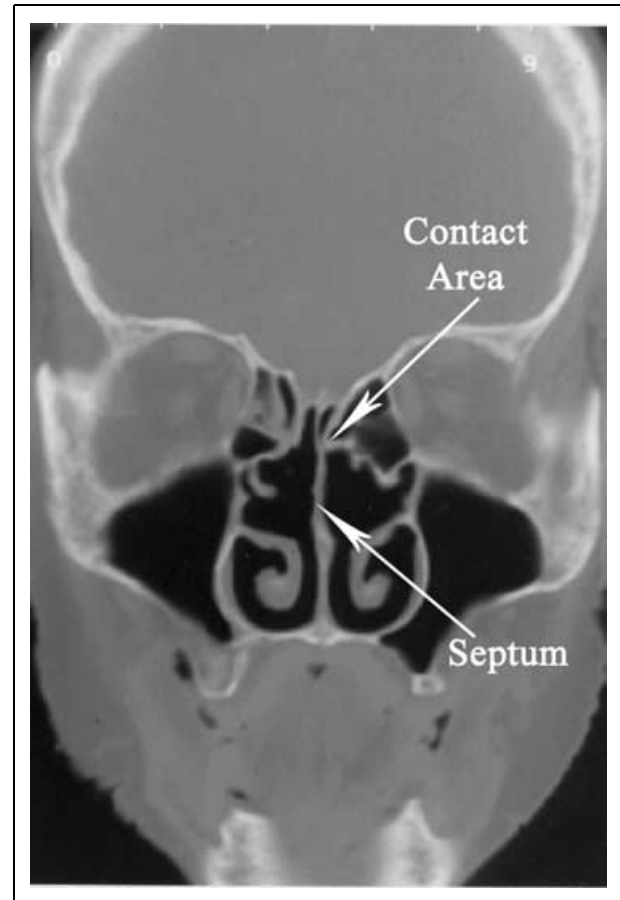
Shown above is a coronal CT of the sinuses. This patient has had a resection of the middle turbinate on both sides in order to relieve headache symptoms, however, there is persistent contact between the medial wall of the ethmoid and the septum on the left.
